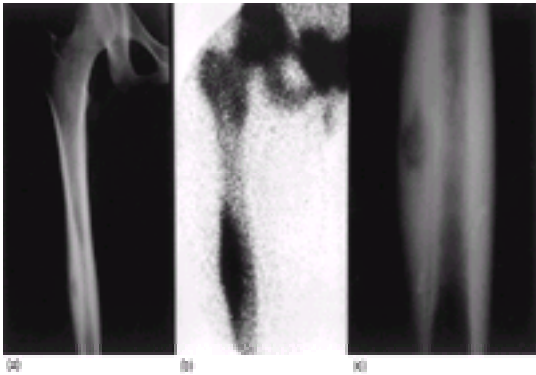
Osteoid osteoma of the femoral diaphysis. (a) Anteroposterior radiograph showing the diaphyseal lucent nidus surrounded by reactive bone; (b) the lesion and new bone show increased uptake on [⁹⁹Tc]-MDP bone scan; (c) tomograms show the nidus, which is centrally mineralized, more clearly.
